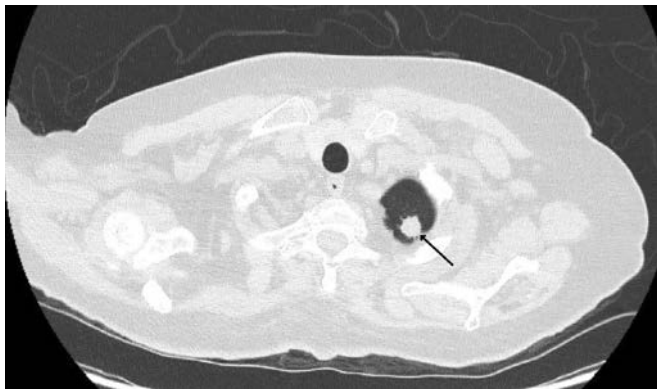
Computed tomography of the chest showing a solid non-calcified pleural base nodule measuring 17 mm in the left apical region (arrow).
